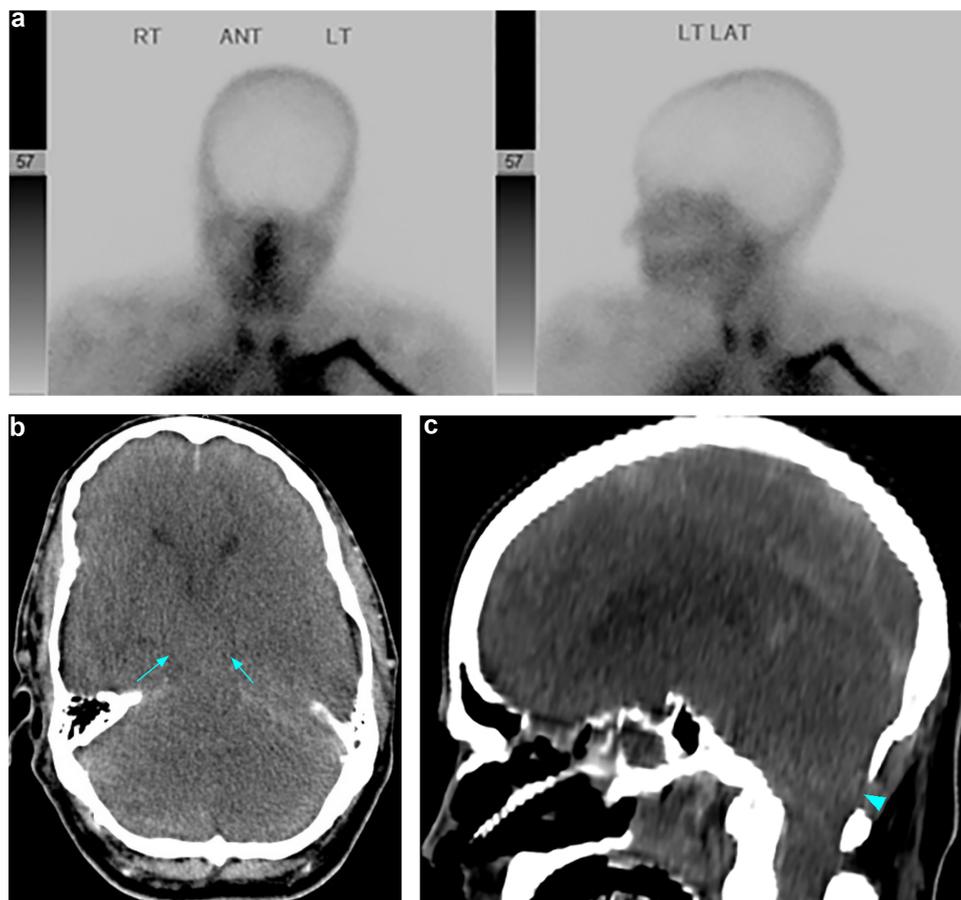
Clinically diagnosed brain death in a 43-year-old male with aortic dissection, post-operative course complicated by ischemic bowel. (a) Tc-99 m HMPAO scintigraphy at the same day of the CT demonstrates no intracranial vascular flow.
